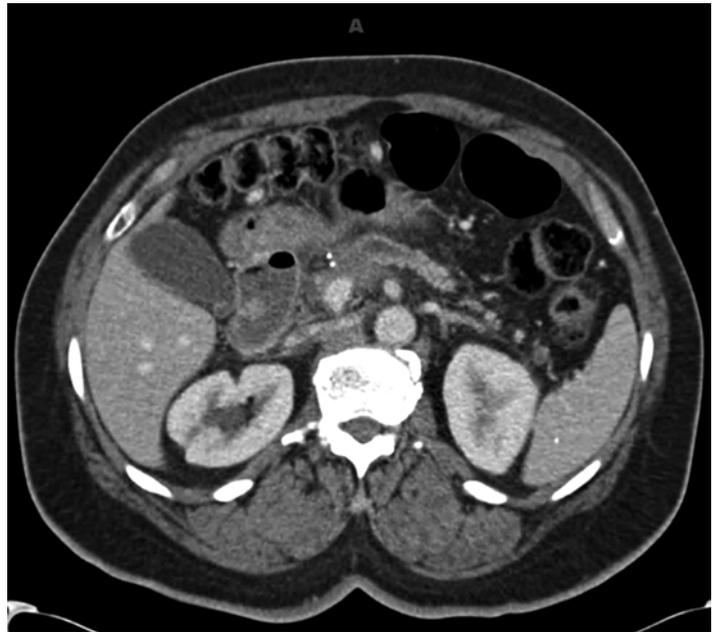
An axial slice from a CT scan of a patient with a hypoattenuating left-sided pancreatic cancer that is invading the portal vein
